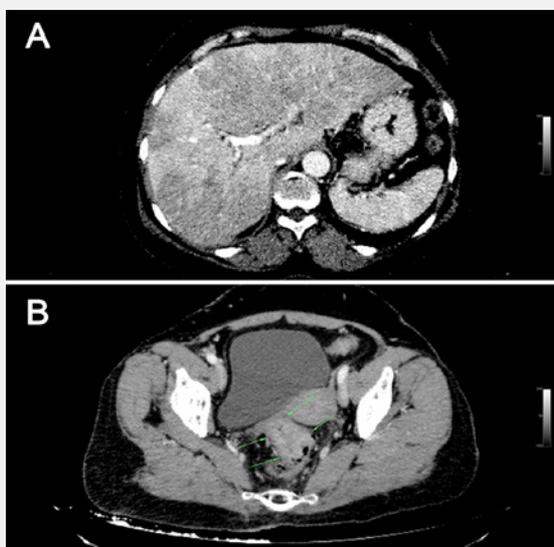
(A) Computed tomography showing numerous hypodense masses throughout the liver consistent with liver metastasis. (B) Contrast-enhanced computed tomography of the pelvis reveals a rectal mass involving the proximal segment of the rectum (shown with arrows).
